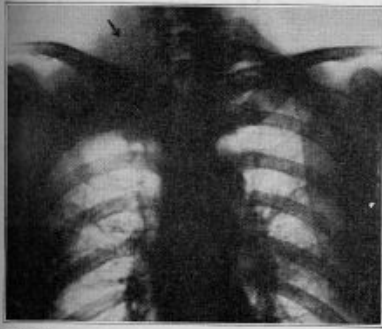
(case 5).—Roentgenogram of the chest, showing an increased density in the right apex and some rib destruction.
